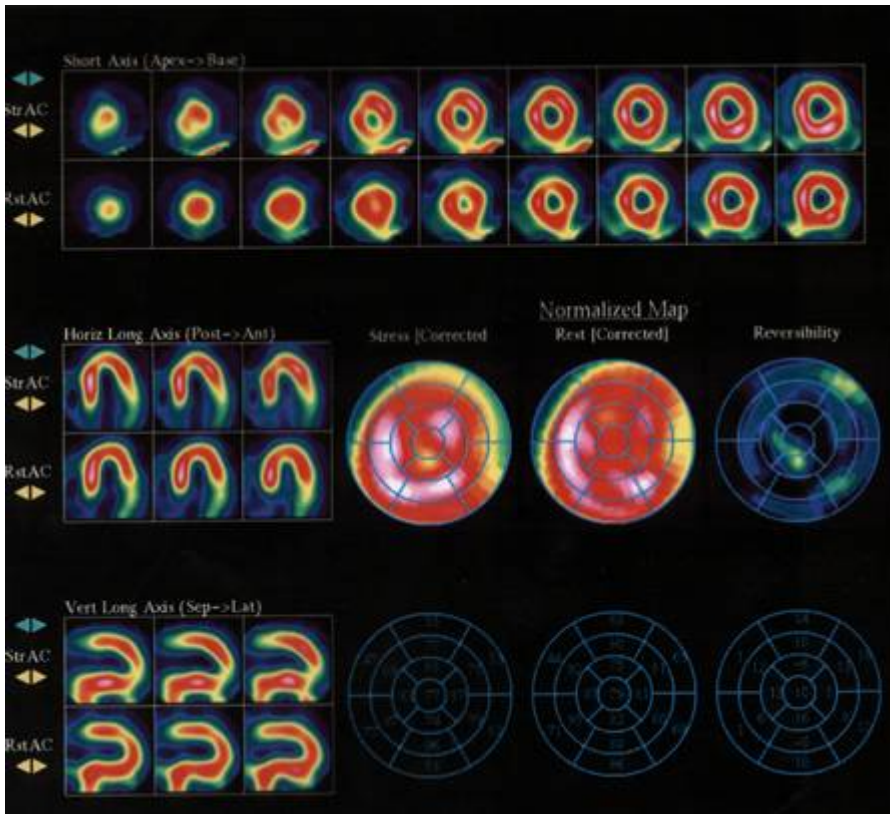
SPECT image of the same patient (Fig F1), 3 months post treatment. The Reversible ischemia that was observed in the apical zone was reduced significantly, resulting in improvement in angina symptoms.
